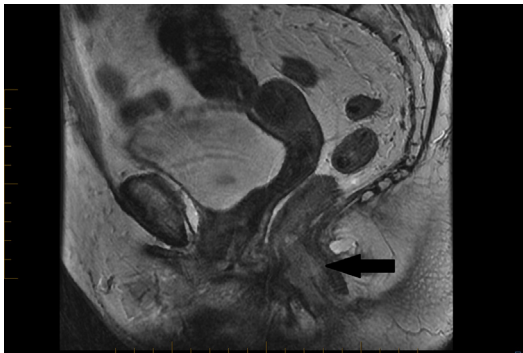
MRI sagittal T2-weighted: anal canal adenocarcinoma (arrow).
